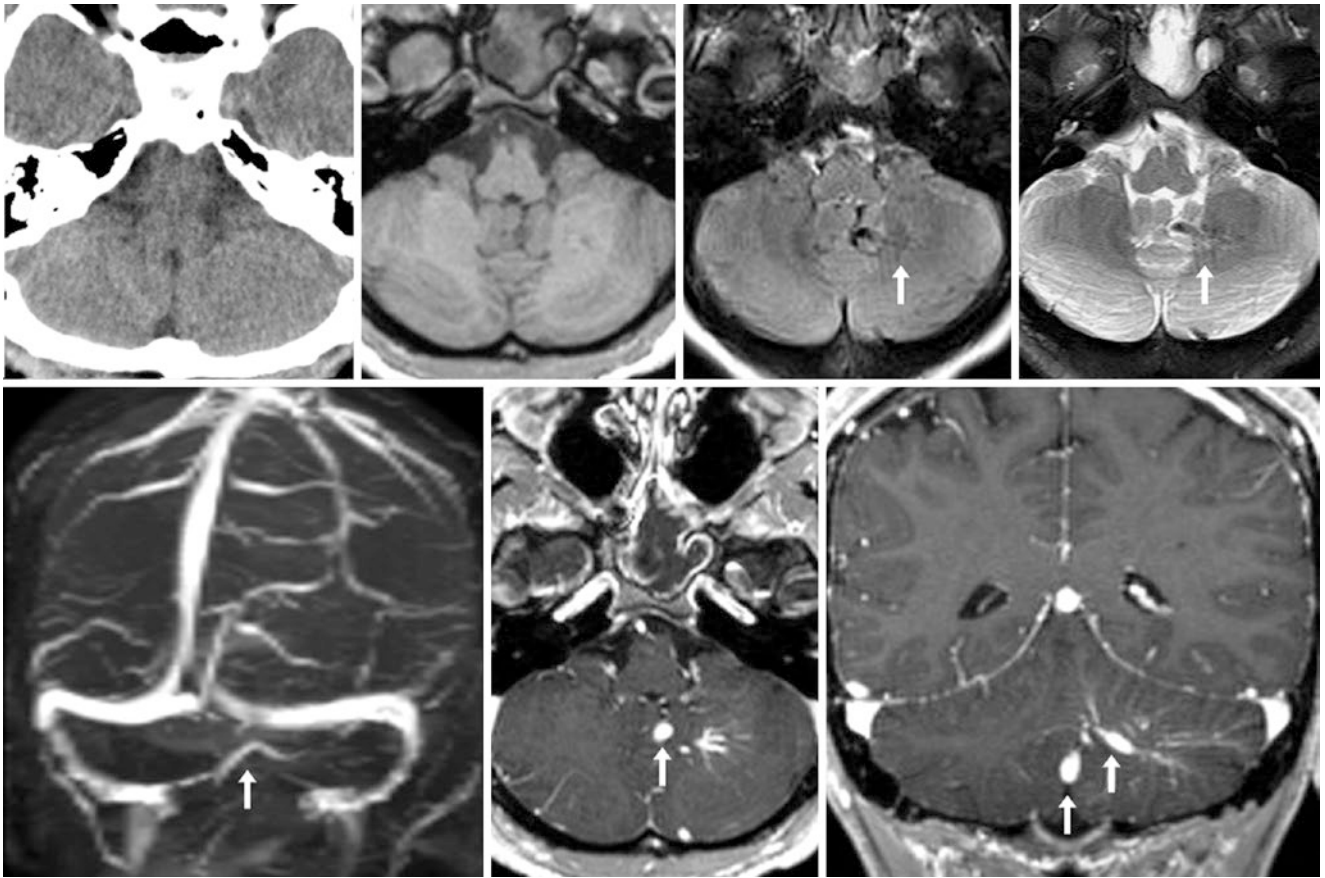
A 25 year old with chronic headaches: axial NECT, GE T1WI, FLAIR, and T2WI (top row, respectively) did not depict a DVA. However, noncontrast TOF MRV (PA view, bottom left) and axial (bottom middle) and coronal (bottom right) GE T1WIs showed a caput of left cerebellar enhancement with an enlarged vein draining medially (arrows)
